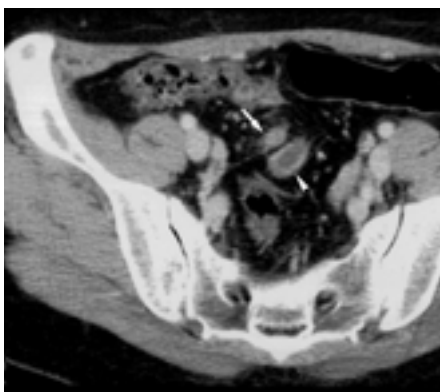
Acute appendicitis in a 34-year-old man. Contrast-enhanced CT scan shows an inflamed distal appendix (arrow-heads) with intraluminal air bubble (thin arrow). Note moderate inflammatory stranding (thick arrow) in periappendiceal mesenteric fat.
